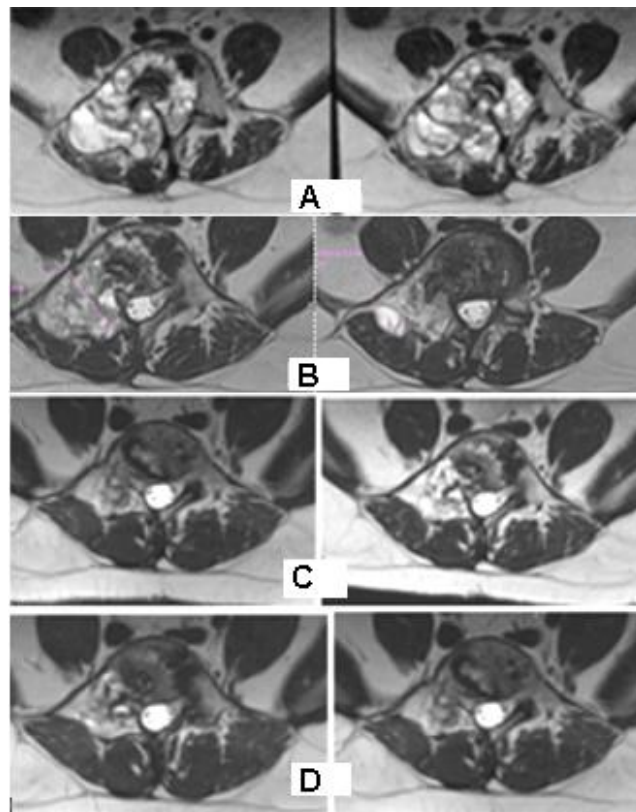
A/ Comparison of MRI before IMRT; B/ MRI after 9 months of IMRT -The structure of the tumor is heterogeneous with confluent hyperintense areas in T2 and STIR, hypointense in T1, as well as the presence of reticular osteosclerotic areas; C/ MRI after 1 year from IMRT /2024 -Residual tumor with axial dimensions of 4.3 / 7.9 cm with transitional 4.3 / 8.4 cm with some advancement of its cystic components. D/ MRI after 2 years from IMRT /2025 -Residual tumor with reduced axial dimensions compared to MRI from 15. 11. 2024 / now 4.01 cm/7.64 cm
